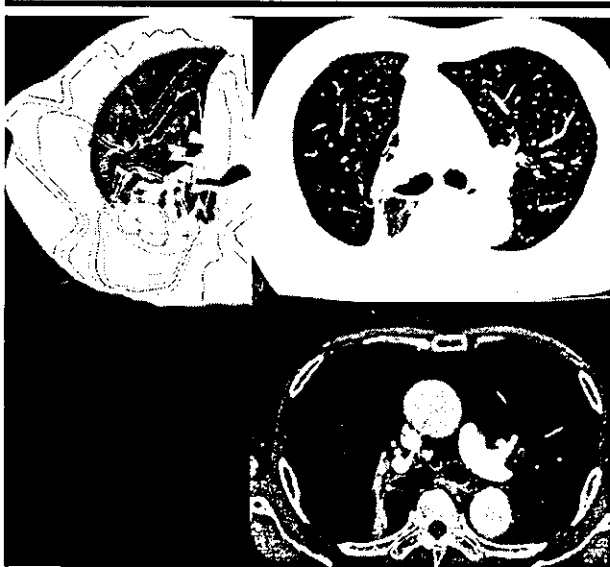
Transverse CT images show a representative case of solid consolidation. Left: Image obtained for treatment planning at the isocenter. Right and bottom: Images obtained 13 months after SRT. Consolidation involving the tumor and surrounding lung tissue in the treatment-planning CT image was observed with the lung window setting (top right), and most of this consolidation was detectable with the soft-tissue window setting (bottom).
